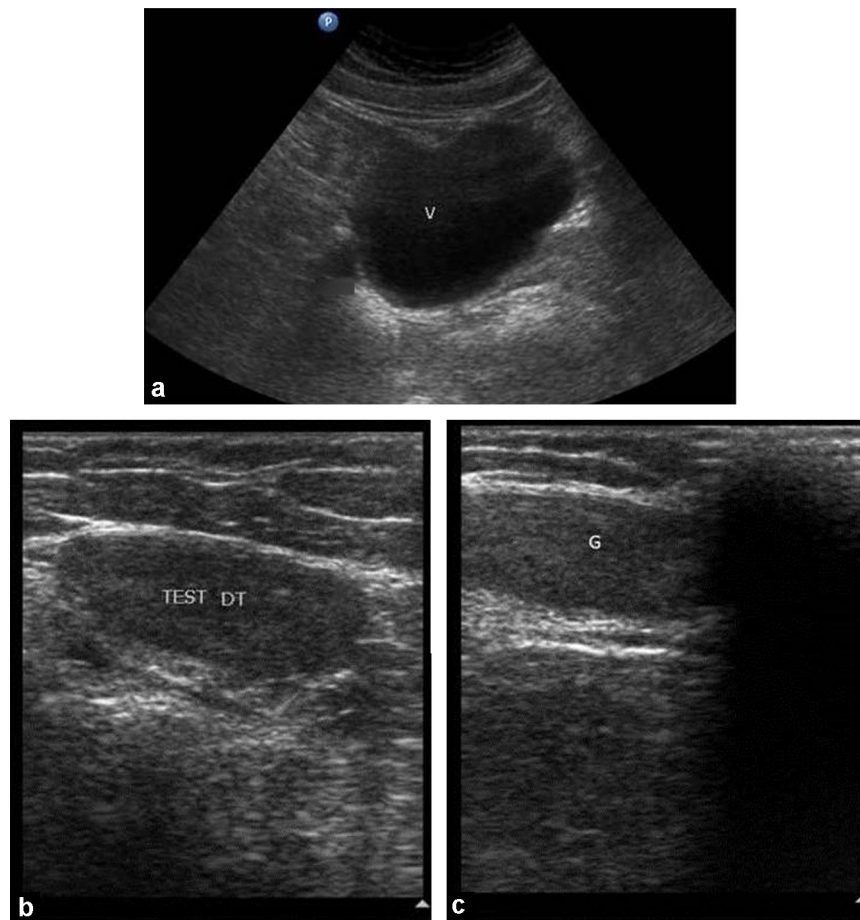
Pelvic ultrasound: sections through the uterine region (a) and through the right (b) and left (c) inguinal structures.
